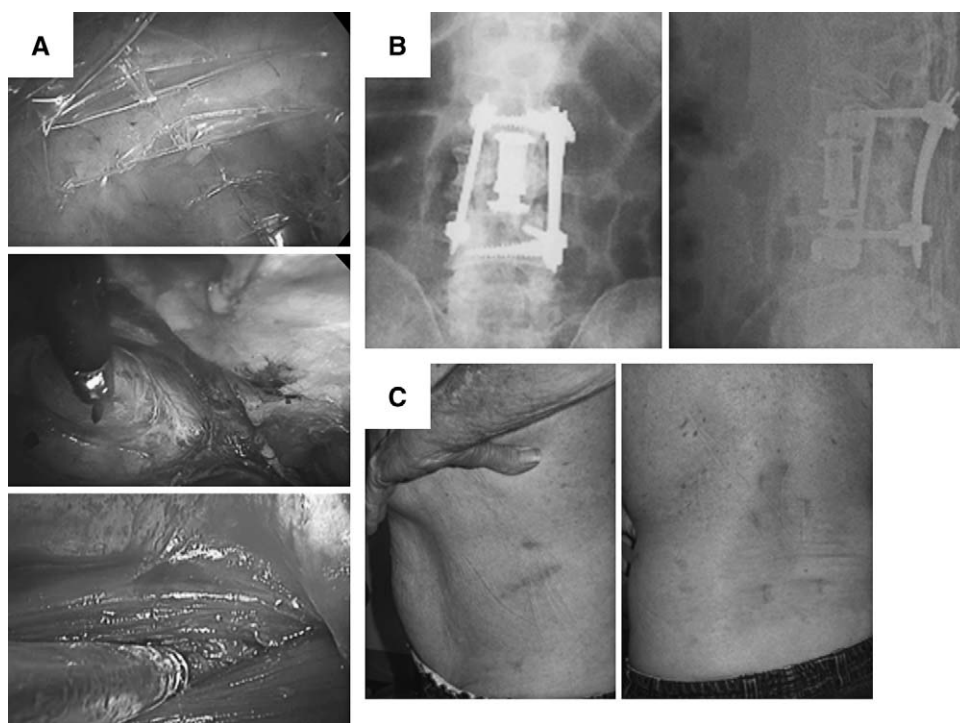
Because unstable osteoporotic burst fractures have been shown to fail at an unusually high rate when a stand-alone anterior approach is used, a short-segment anteroposterior construct, with both stages being performed in a minimally invasive fashion, may be a preferential form of treatment. Shown are the intraoperative images (A), postoperative radiographs (B), and clinical images (C) of a 75-year-old man with a chronic osteoporotic burst fracture requiring a laparoscopic-assisted L3 vertebrectomy augmented with percutaneous pedicle screw instrumentation. Operated on for progressive paraparesis because of incessant collapse, he required a walker for ambulation before surgery as the result of a bilateral foot drop. Three years out from surgery, although originally on chronic narcotics, he is off pain medication, neurologically improved to normal, and walking independently, without a significant loss of correction.
